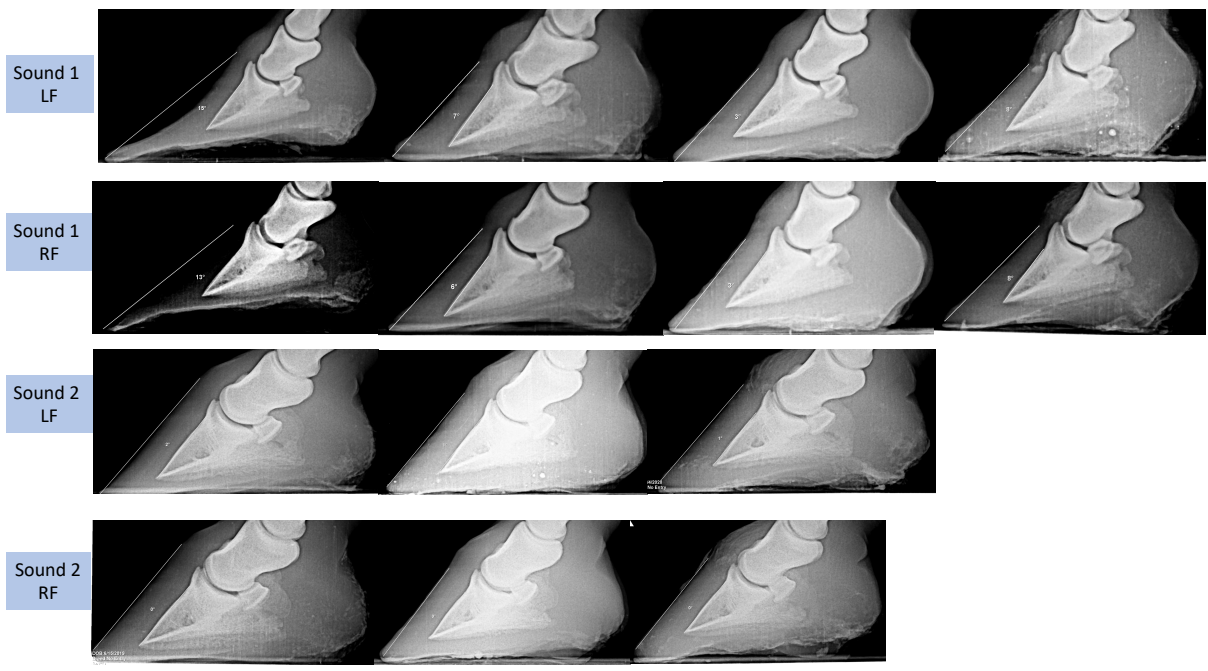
Radiograph images of the right and left forelimbs of the two sound equids with rotational measurements. Progressing from day 57 (first trim), 115 (first shoeing), 162 (second shoeing), and (261 final shoeing) from left to right.
